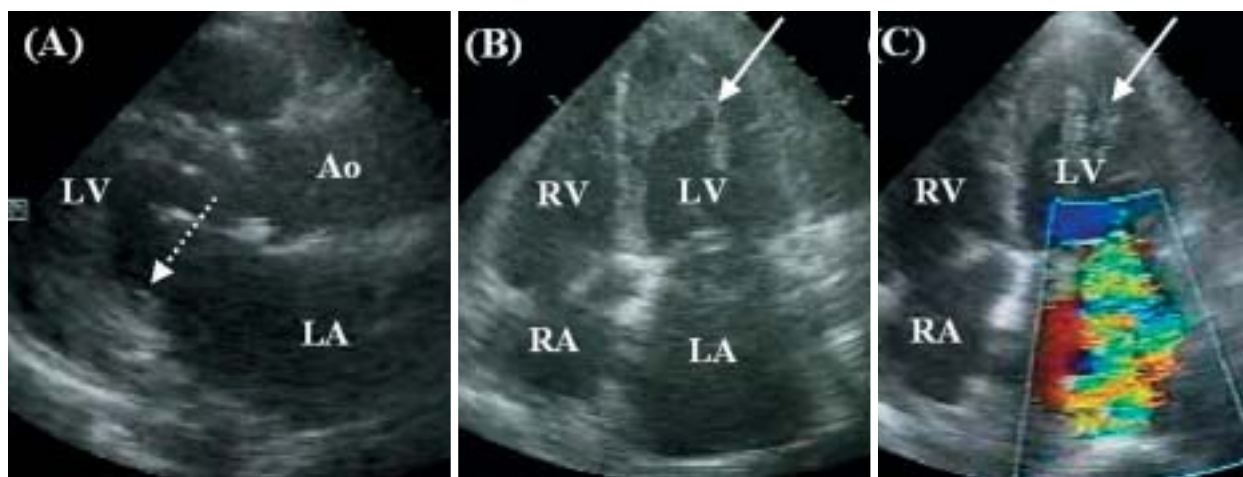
Transthoracic echocardiograms
